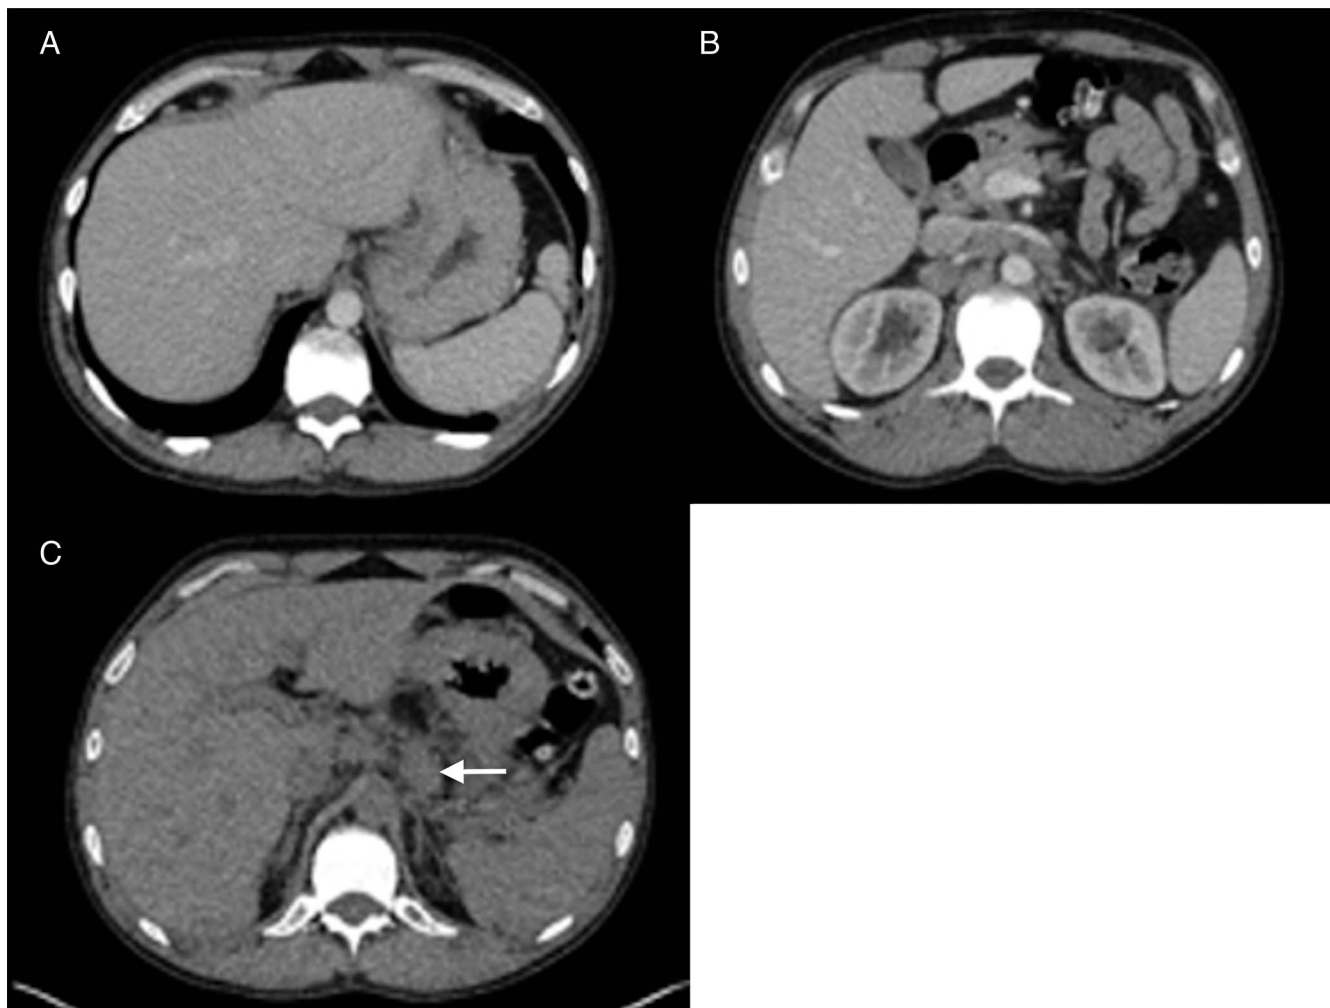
Abdominal computed tomography scan. (A) Significant thickening of the gastric fundus measuring up to 27 mm. (B) Extensive retroperitoneal lymphadenopathy in the para-aortic and aortocaval regions. (C) Enlargement of the gastrohepatic lymph node (white arrow) measuring 24.5×29.6 mm.
